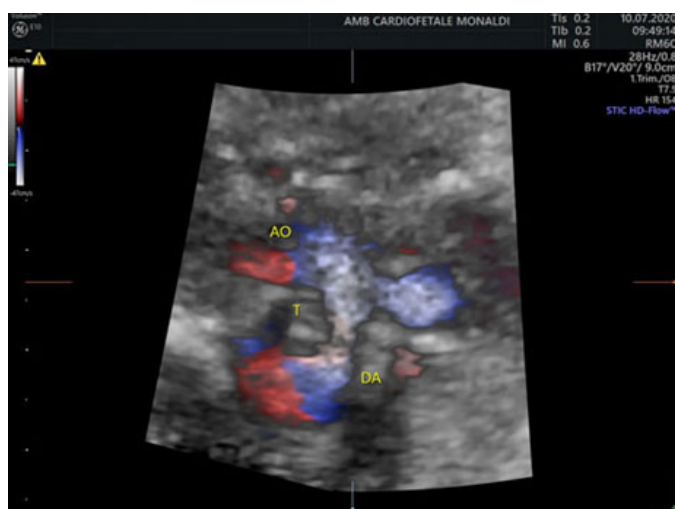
Three-dimensional color Doppler image, course of the aortic arch and ductal arch. Trachea (T), aortic arch (AO), and ductal arch (DA).
